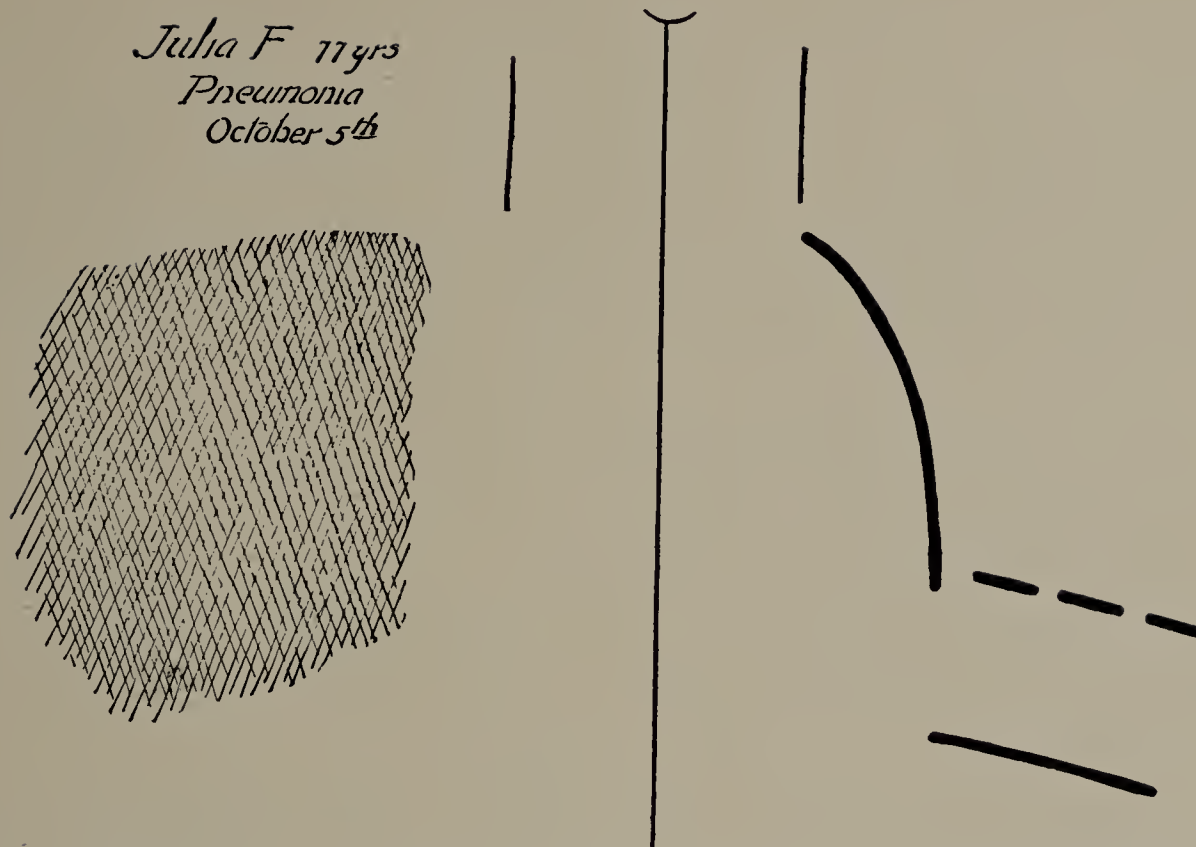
Julia F. October 5. First X-ray tracing. Pneumonia, right side. Diaphragm lines obliterated on this side. (One-third life size.)
